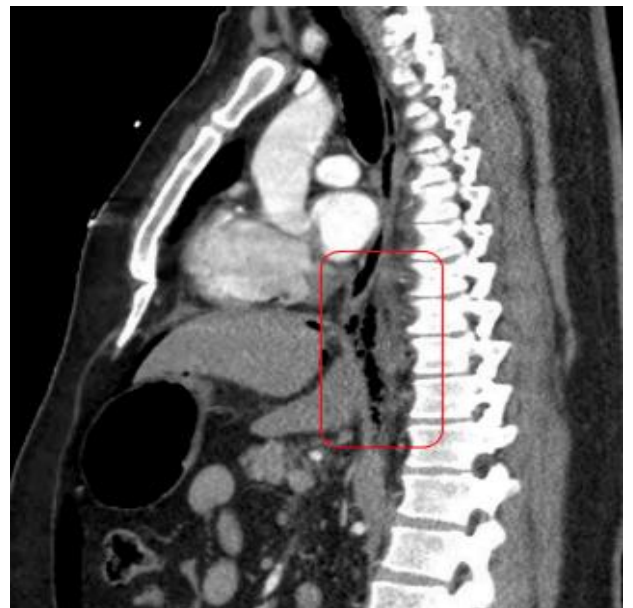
CT showing pneumomediastinum and pneumoperitoneum, suggesting esophageal injury near the GE junction (red box).
